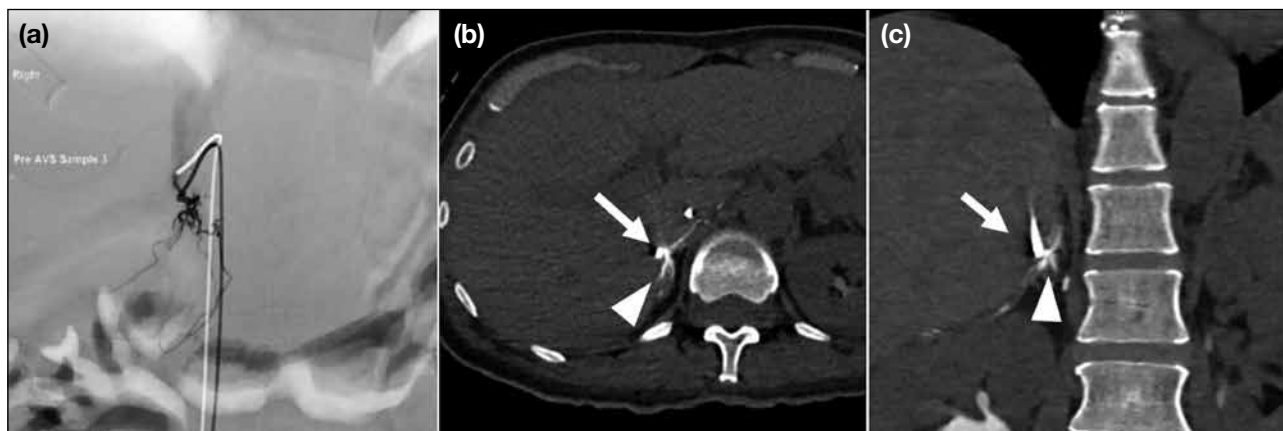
(a) A 42-year-old female patient. During second trial of adrenal venous sampling (AVS), the right adrenal vein was cannulated with a catheter (Yashiro; Terumo, Tokyo, Japan). Right adrenal venogram shows the spidery configuration of the right adrenal vein, similar to previous AVS. (b, c) Angiography–computed tomography right adrenal venogram before sampling shows catheter tip (arrows) was within the right adrenal vein, with contrast opacification of the right adrenal gland (arrowheads). There was no accessory vein draining to the right adrenal vein. The injection protocol via the 5-Fr Yashiro catheter was: 6 mL undiluted contrast at 1 mL/sec, with computed tomography acquisition at 4 seconds after start of contrast injection.
